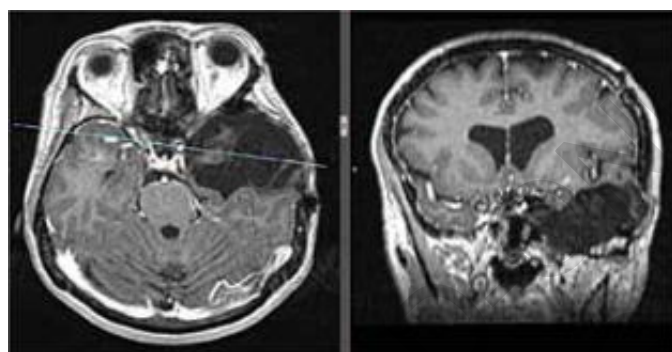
7 years post-op control MRI.
